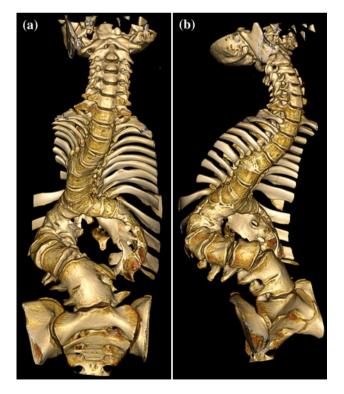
Coronal (a) and right oblique (b) 3D volume rendering CT images show marked duplication and separation of the thoracolumbar spine and rotoscoliosis
